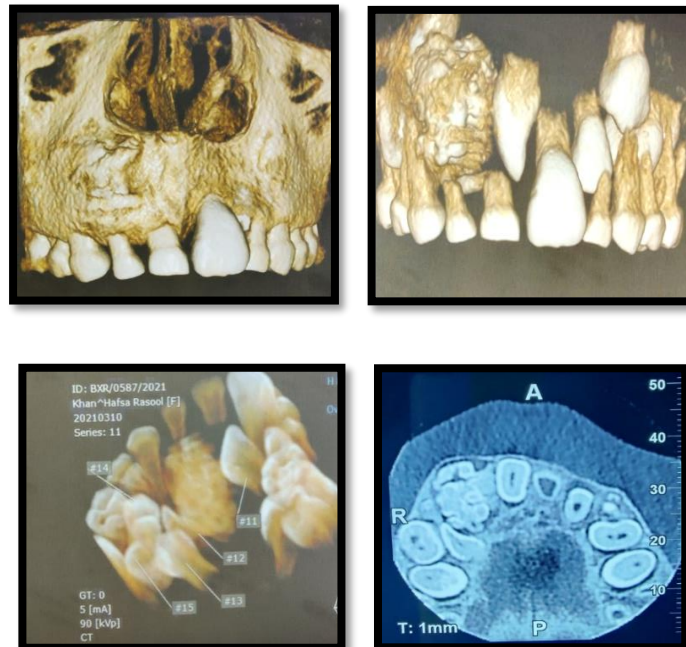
CBCT Findings showing radio opaque mass in region of 51 to 53
